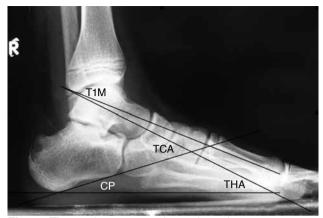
The angles measured on a lateral roentgenogram. TCA: Talocalcaneal angle; T1M: Talo-first metatarsal angle; CP: Calcaneal pitch angle; THA: Talohorizontal angle.
